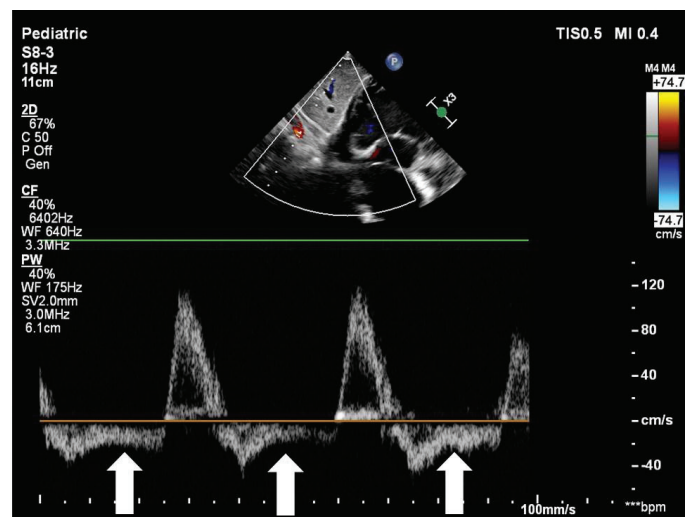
Pulsed-wave Doppler image of the abdominal aorta showing obvious holodiastolic flow reversal/run-off phenomenon (white arrows).
